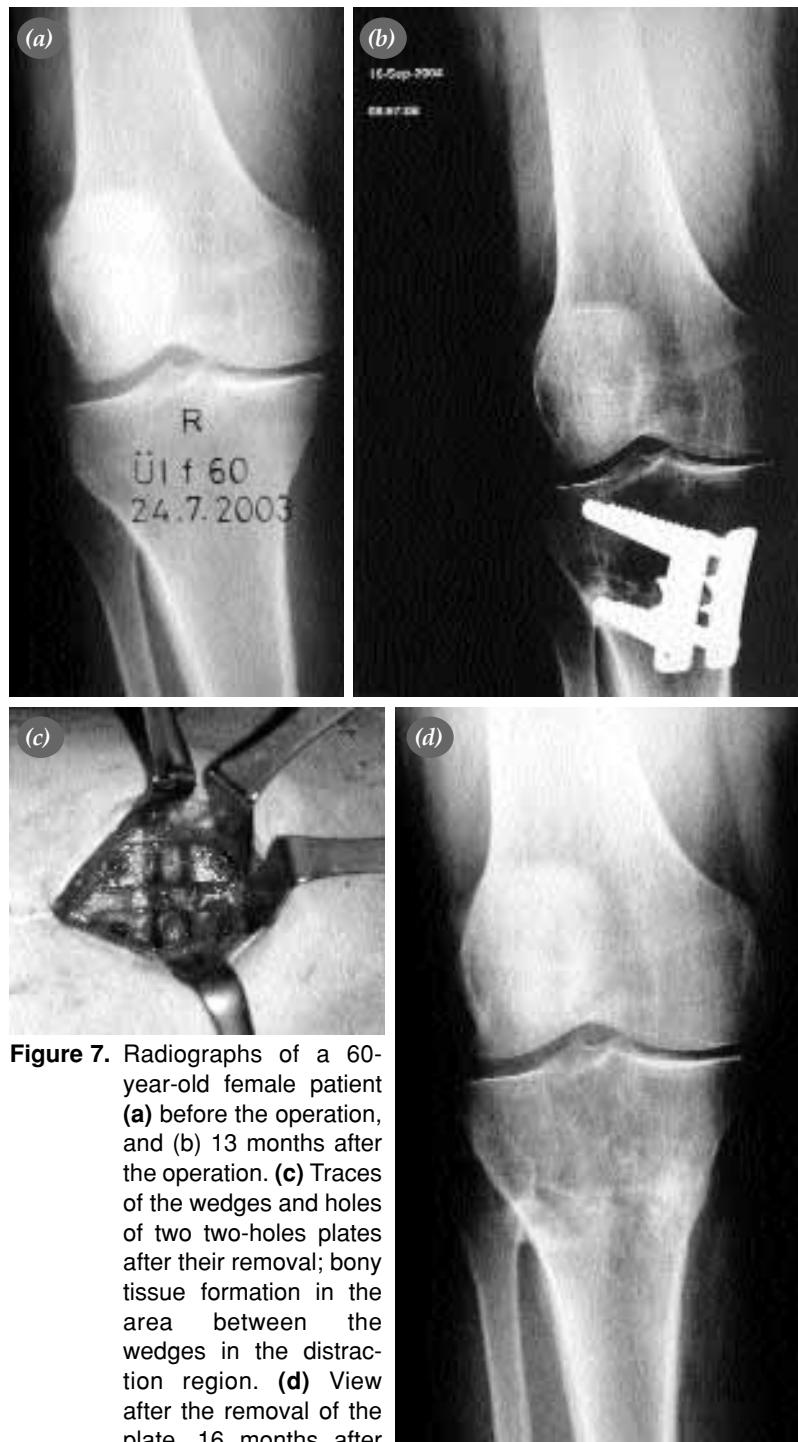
Radiographs of a 60-year-old female patient (a) before the operation, and (b) 13 months after the operation. (c) Traces of the wedges and holes of two two-holes plates after their removal; bony tissue formation in the area between the wedges in the distraction region. (d) View after the removal of the plate, 16 months after the first operation.
